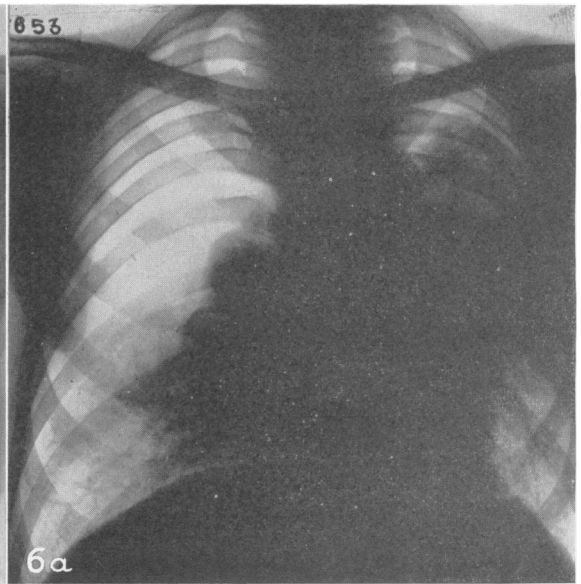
Case 7 Aged 41: eleven years a candle turner. Radiograph taken April, 1945.
